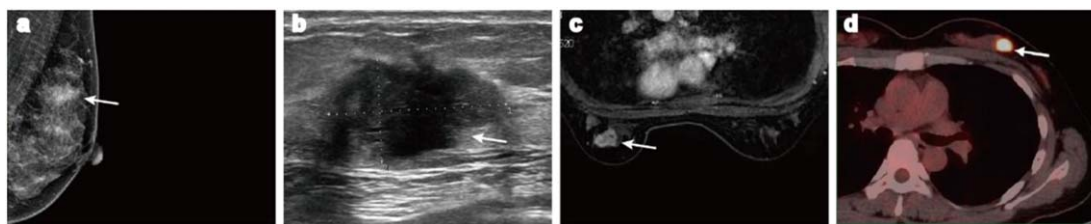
Digital MG, US, MRI and PET-CT scans of a 42 y old woman with an infiltrating ductal carcinoma in the left breast, indicated with the white arrows. (a): MG, (b): US, (c): MRI, (d): PET-CT.
